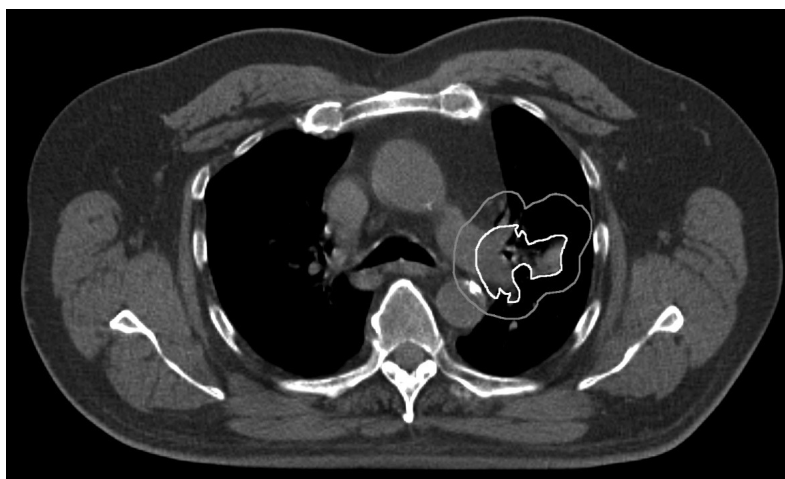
Example of typical transversal CT slice of a patient included in the study showing large difference in the planning target volume (PTV) (grey line) and the gross target volume (GTV) (white line) volume as well as large lung volume included in the PTV
